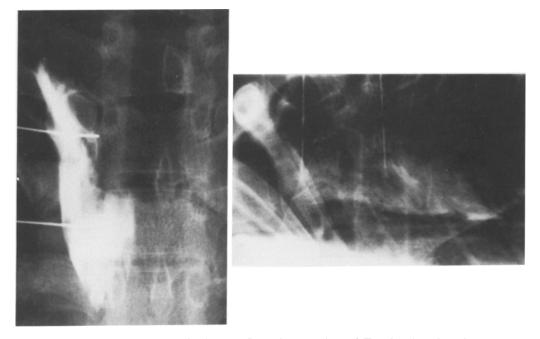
These are a A-P and a lateral X-ray films of T2 and T3, showing that the contrast medium has spread from the lateral margin of the vertebral body to beyond the midpoint of the costal processes and to the posterior margins of the lateral surface of the 2nd and 3rd thoracic vertebra.
